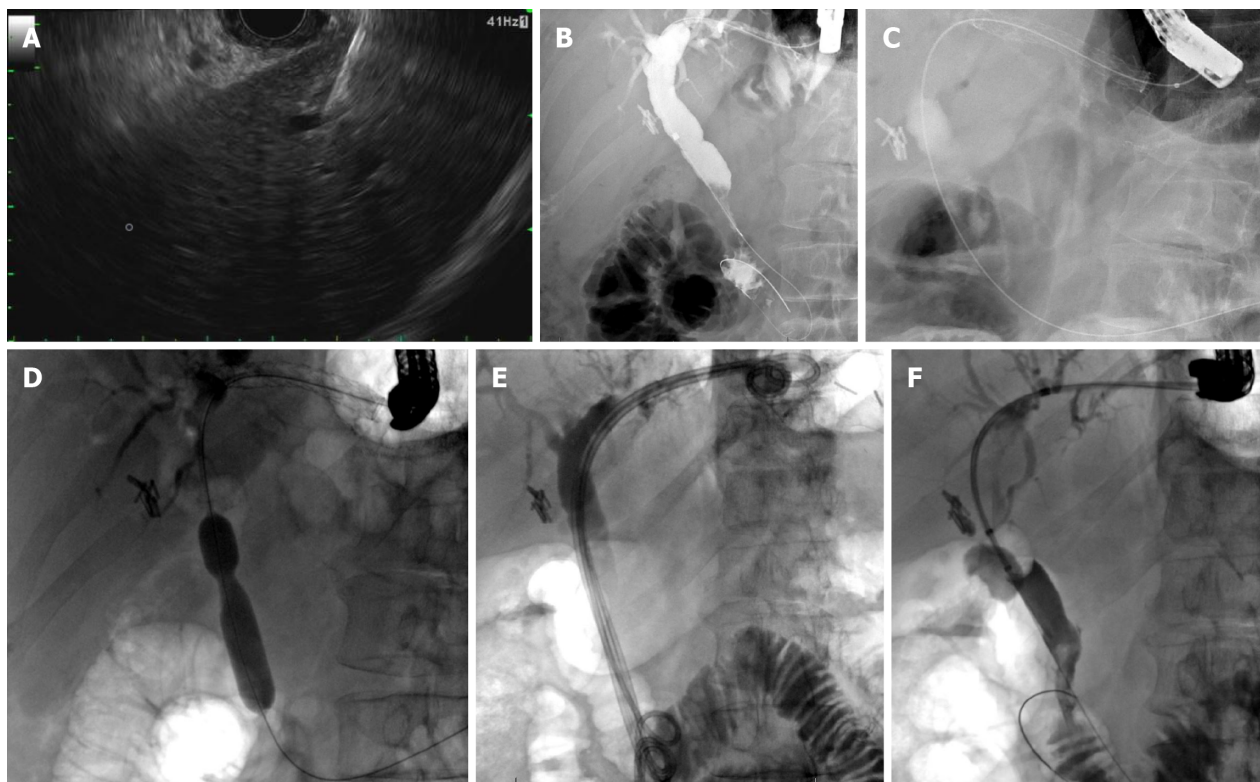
Endoscopic ultrasound-guided hepaticogastrostomy for benign distal biliary stricture in a patient with history of roux-en-Y gastric bypass surgery. A: Endoscopic ultrasound-guided puncture of a dilated B3 radical with a 19-gauge needle; B: Fluoroscopic image showing a dilated bile duct with distal biliary stricture; C: Fluoroscopic image showing placement of a fully covered hepaticogastrostomy metal stent; D: Antegrade balloon dilation of the distal bile duct stricture using a wire-guided balloon; E: Successful placement of four 7 Fr × 18 cm double pigtail biliary stents with the distal end past the ampulla in the small bowel and the proximal end in the stomach; F: Occlusion cholangiogram following removal of plastic hepaticogastrostomy stents showing resolution of distal bile duct stricture with free flow of contrast into the small bowel.
